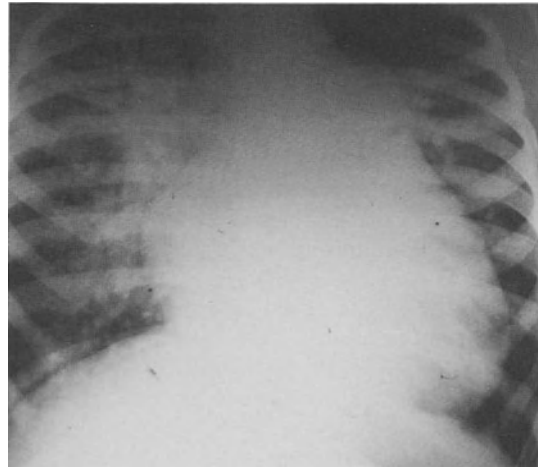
X-ray in ventricular septal defect with large left-to-right shunt and pulmonary hypertension.
